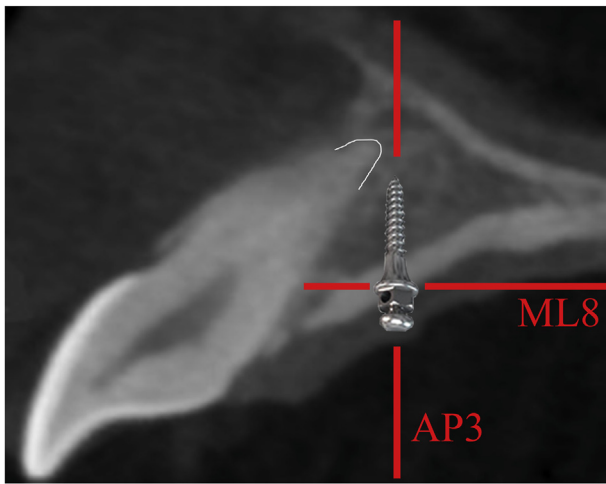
A sagittal section of CBCT image at the zone, 3-mm posterior to the posterior rim of the incisive foramen and 8-mm lateral to the midsagittal line (AP3/ML8) of an adolescent. TAD insertion at AP3/ML8 site may damage the root of incisors.
